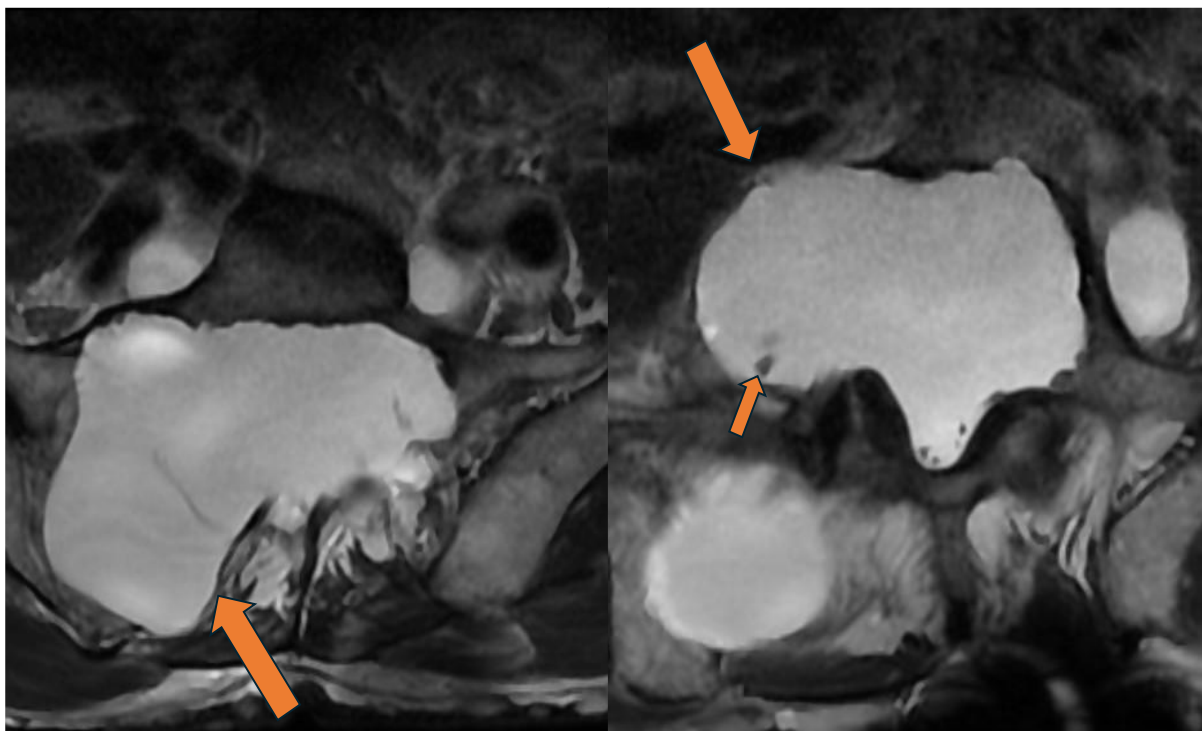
Axial T2-weighted MRI of the lumbosacral spine demonstrating a large multiloculated lumbosacral meningocele with internal septations and associated posterior vertebral scalloping.
